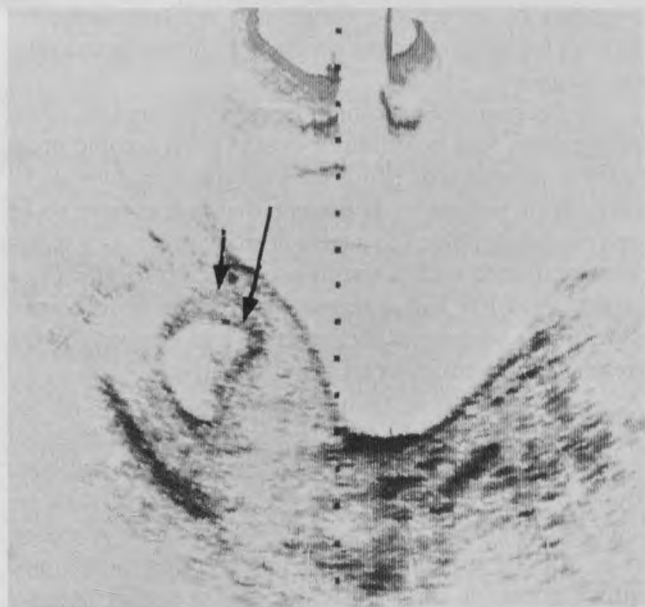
Pelvic ultrasonogram demonstrating the "double sac sign" indicative of an intrauterine gestation. The concentric echogenic rims correspond to the decidua capsularis (long arrow) and the decidua parietalis (short arrow).
